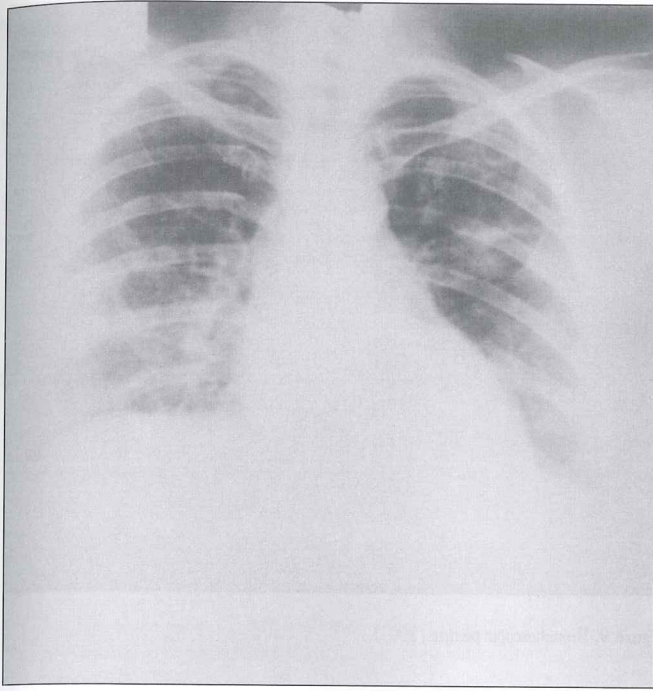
Postero-anterior chest X-ray (2001)
